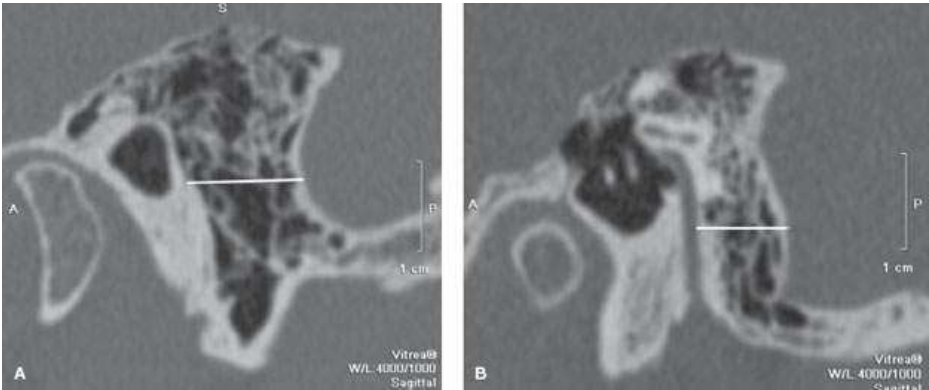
Anterior position of the sigmoid sinus as examined on sagittal computed tomography images. The anteroposterior width between the sigmoid plate and either the tympanomastoid suture (A) or the descending portion of the facial nerve (B) is measured (white line). Normal values are \$1 cm.
